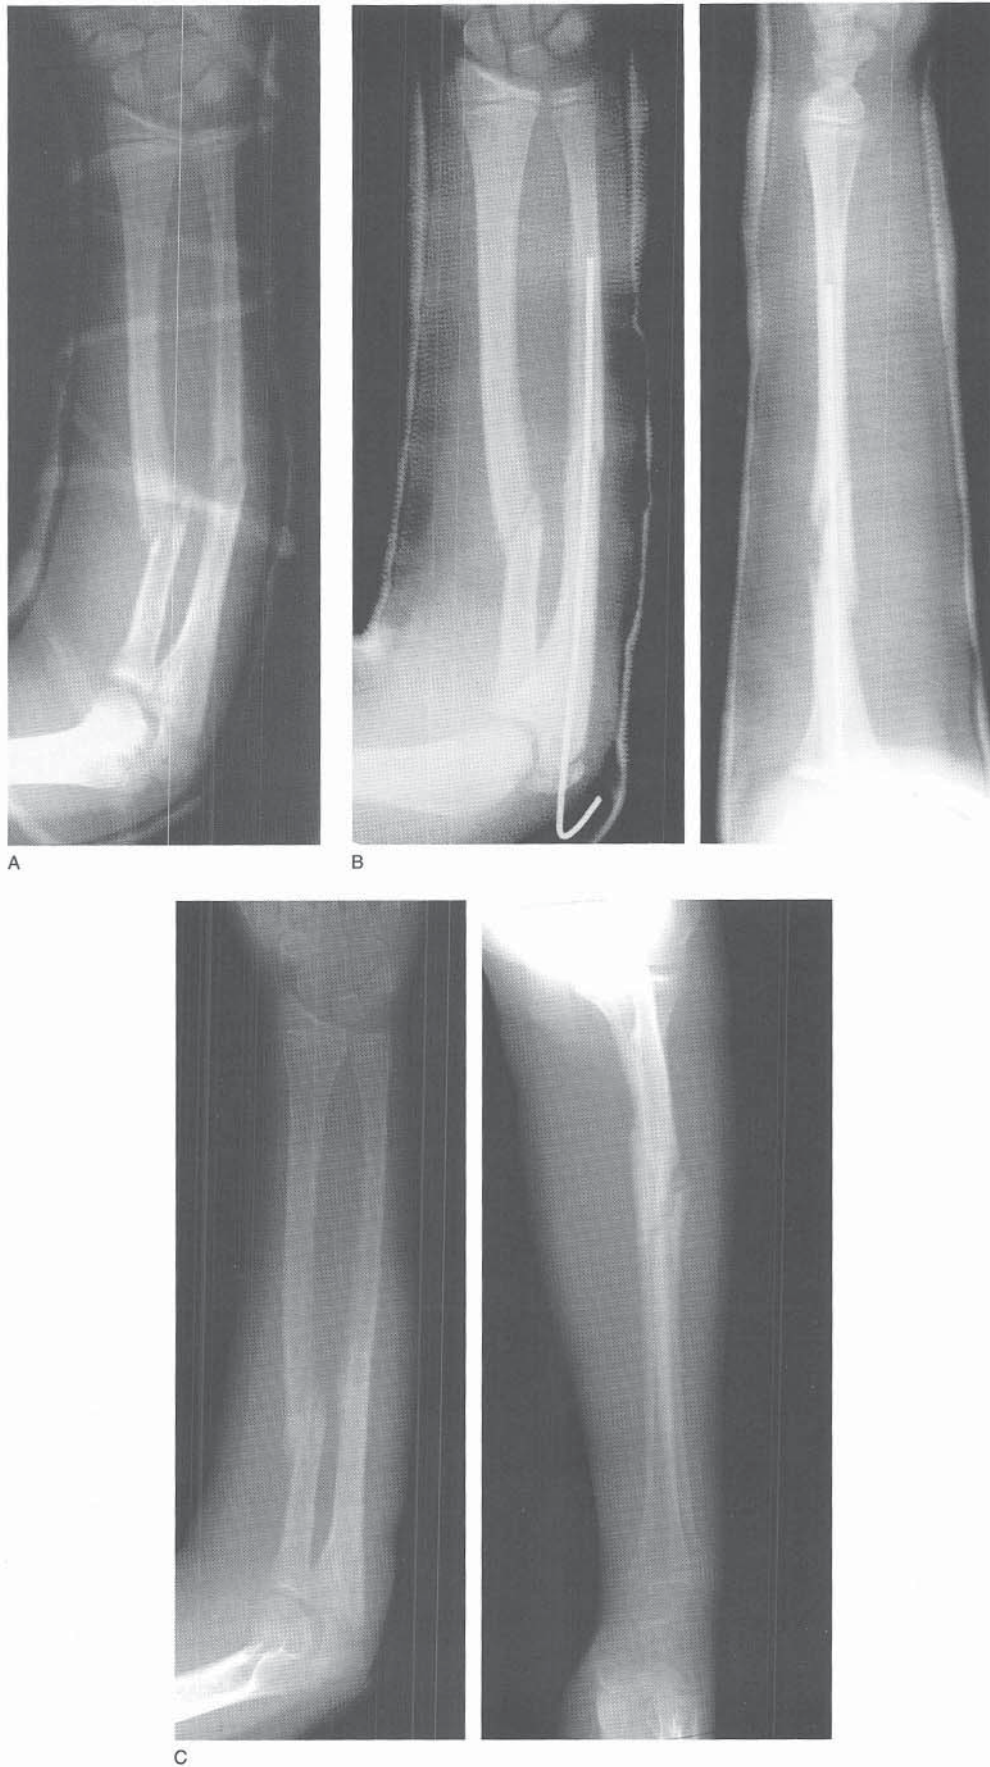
Single-bone fixation of both-bone forearm fracture. A, AP radiograph of a both-bone forearm fracture with the radius fractured proximal to the ulna. Note the ulnar deviation in the cast approximately 2 weeks after injury. B, AP and lateral radiographs following open reduction and pin fixation of the ulna. Note that fixation of the ulna has improved the alignment of the radius. C, AP and lateral radiographs following cast and pin removal.
